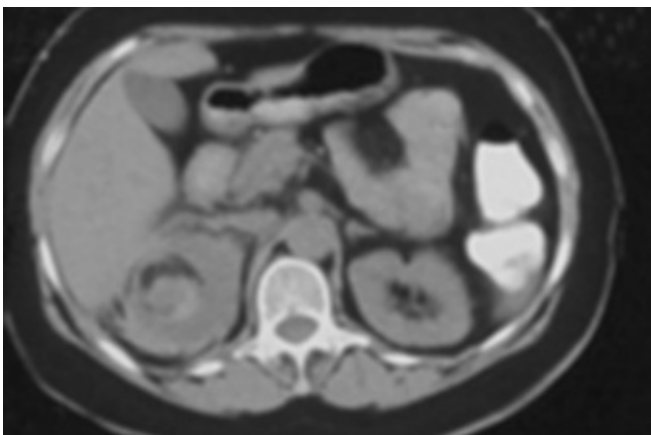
Unenhanced CT scan shows heterogeneous mass. A small fat-dense lesion is seen in the periphery of the mass and perirenal hemorrhage.
